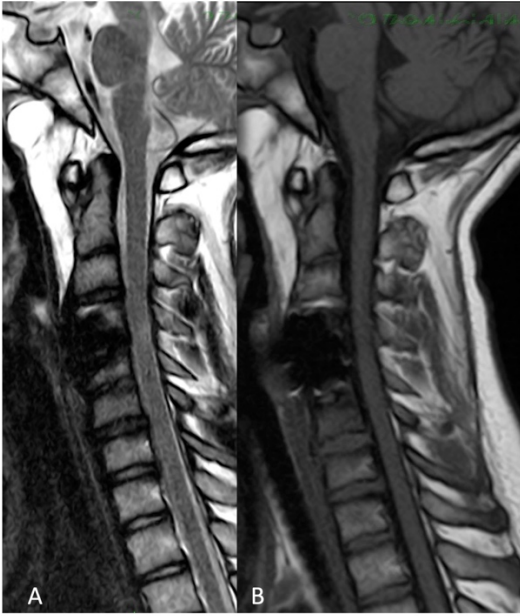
Follow-up MRI A-B) Six-months follow-up MRI in T1 (A) and T2 (B) weighted image showing the radiological improvement of preoperative sign of myelopathy.
